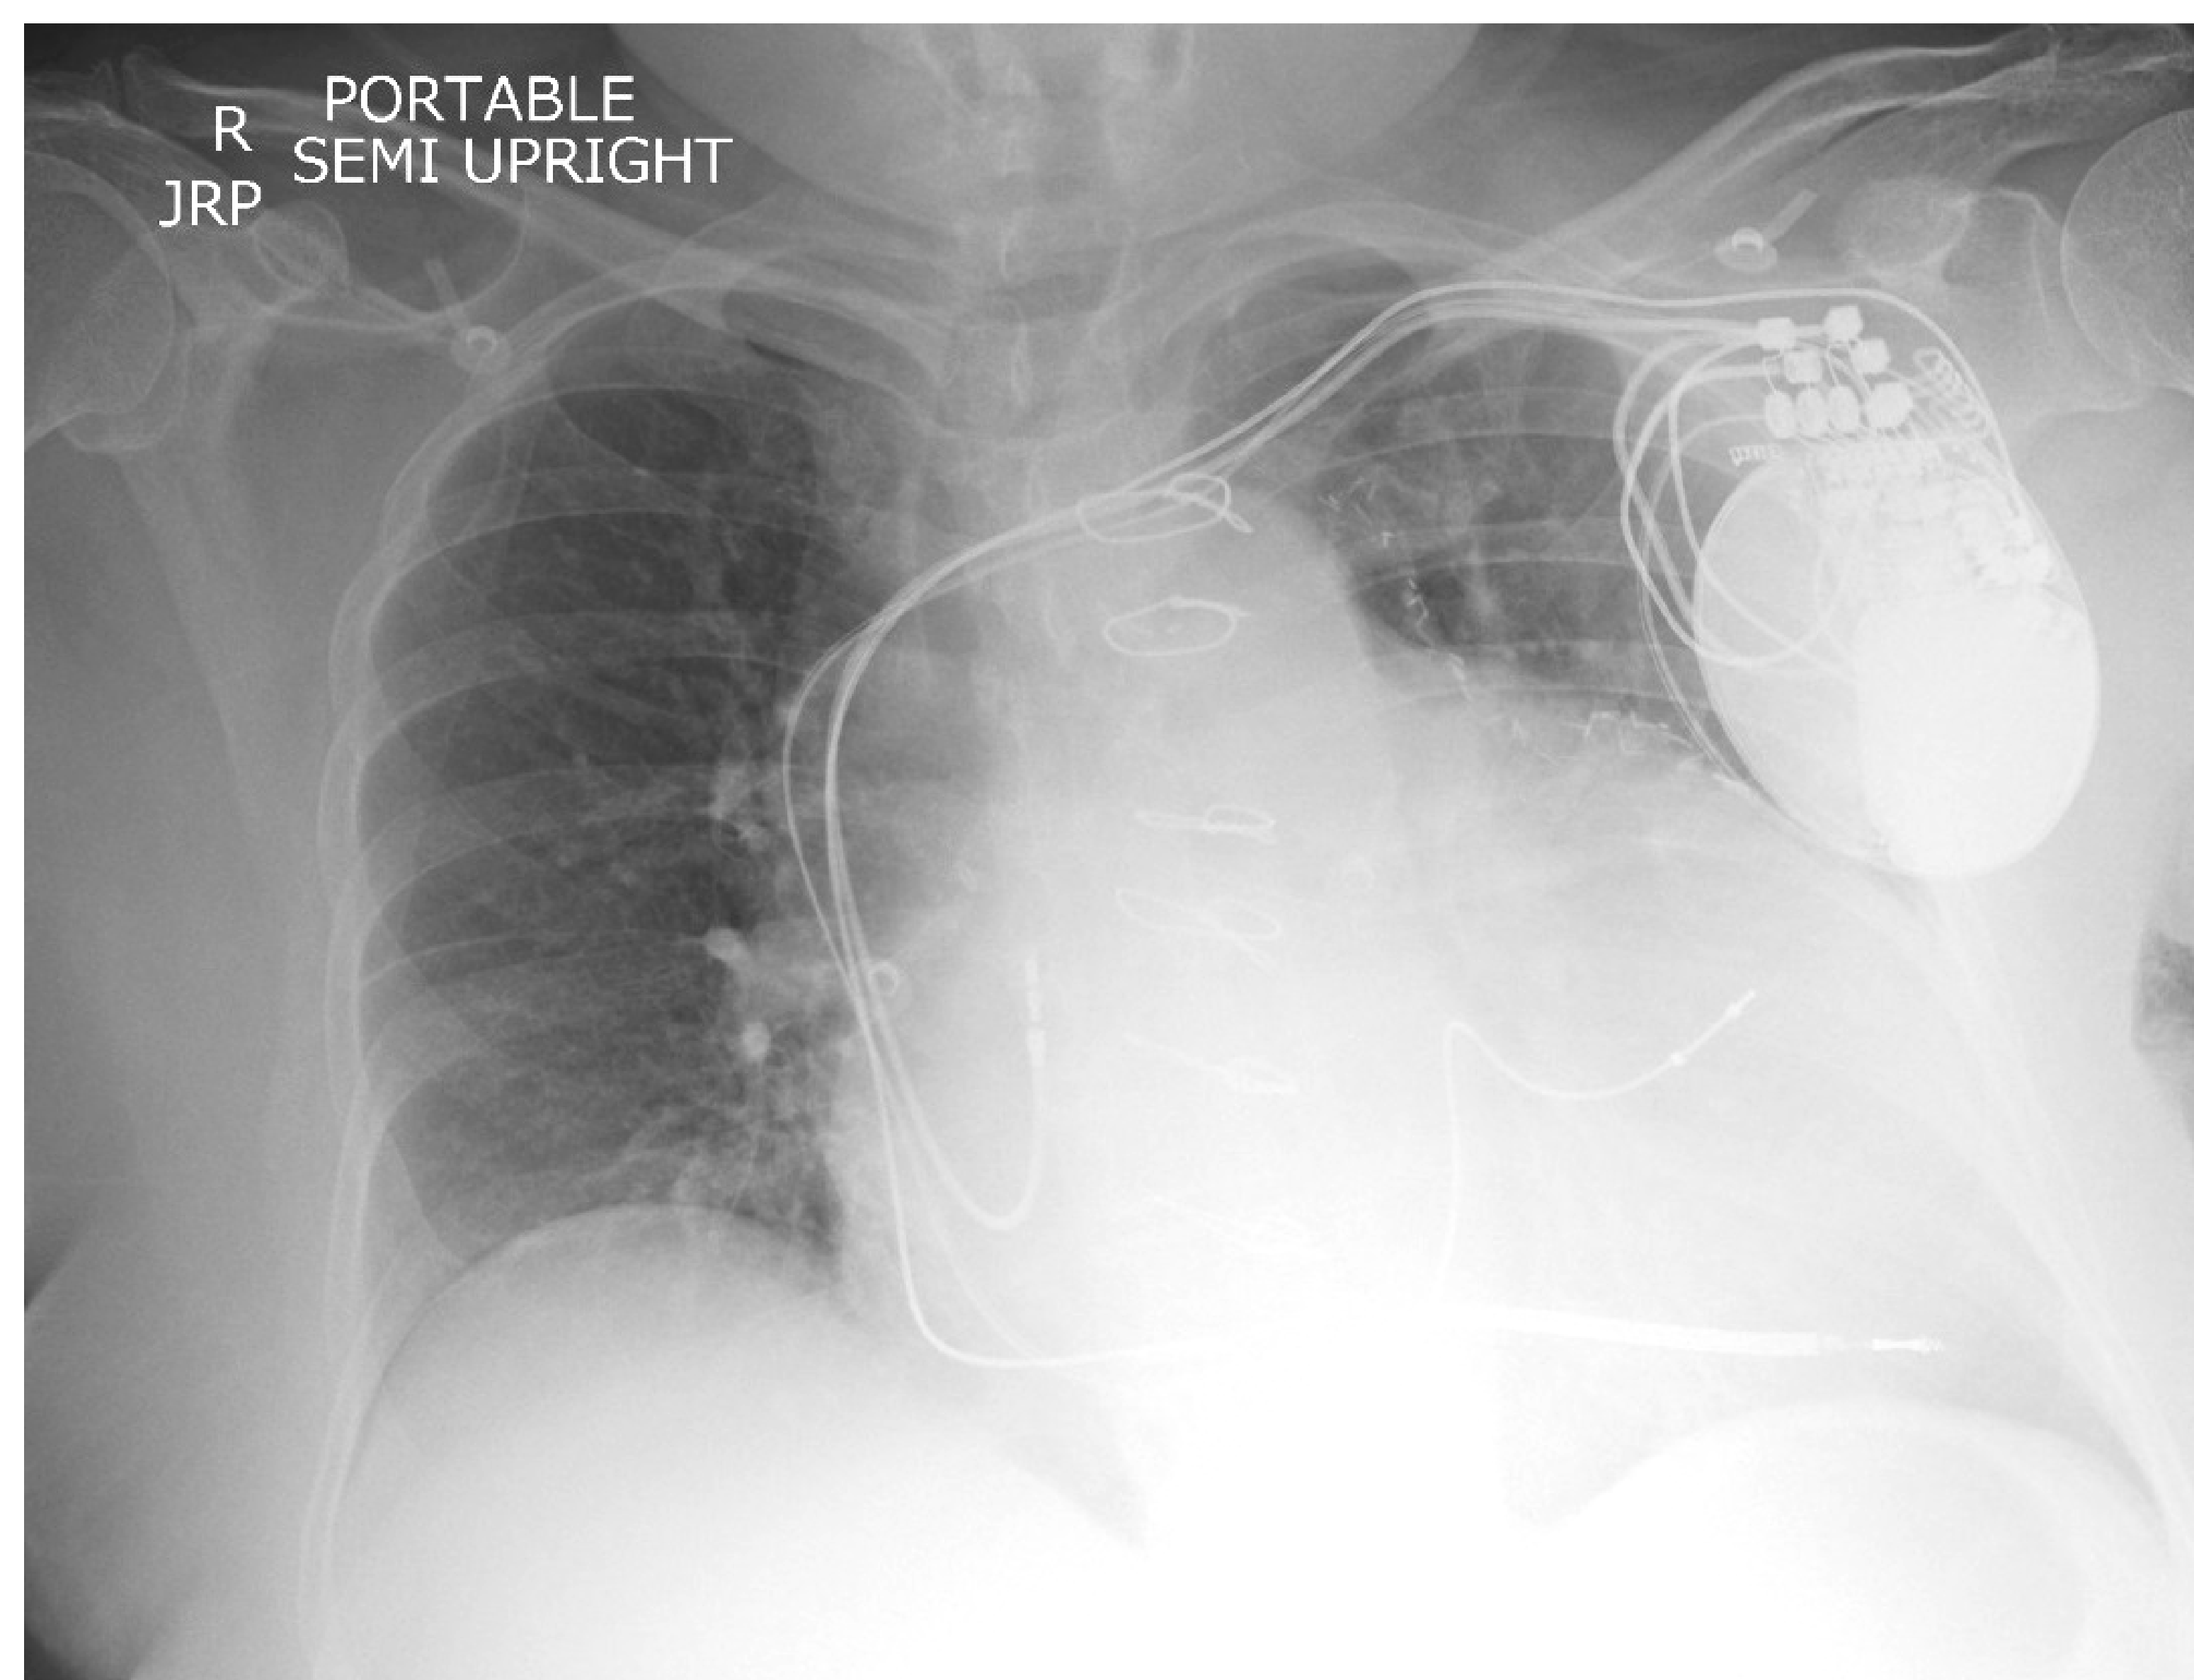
Initial chest x-ray
